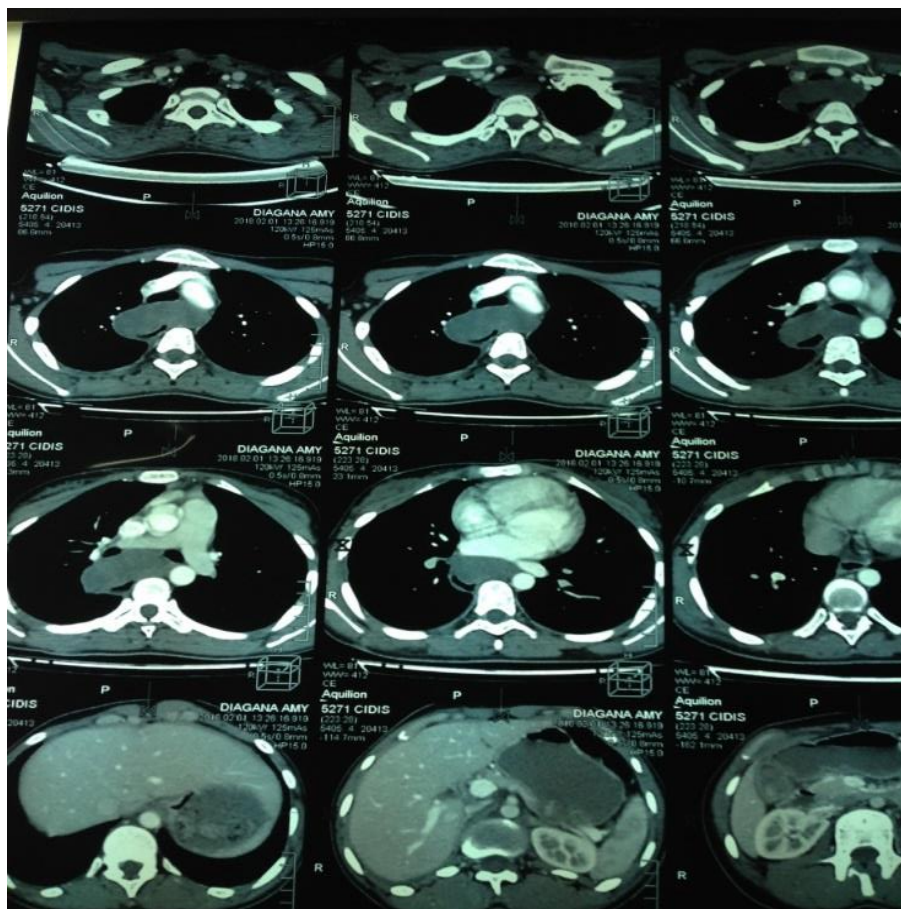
CT appearance of posterior mediastinal mass
